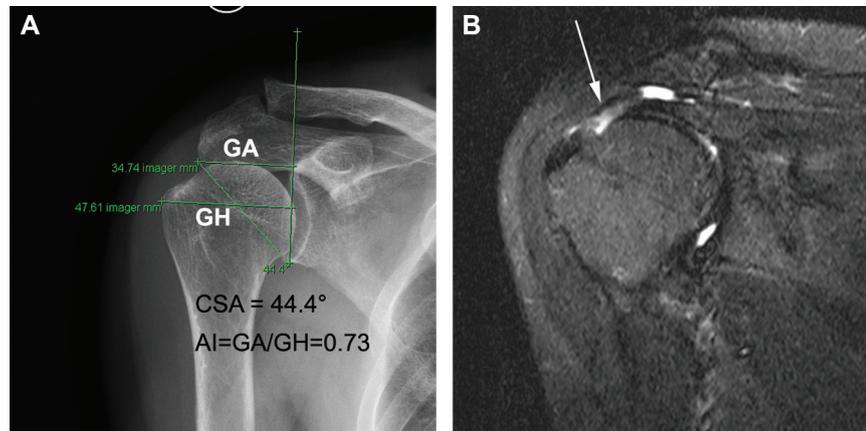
A 43-year-old woman with a large critical shoulder angle (CSA) had a tendon retractor: (A) radiograph and (B) magnetic resonance image. White arrow indicates retractor tendon. (See Figure 3 for angle definitions.)
